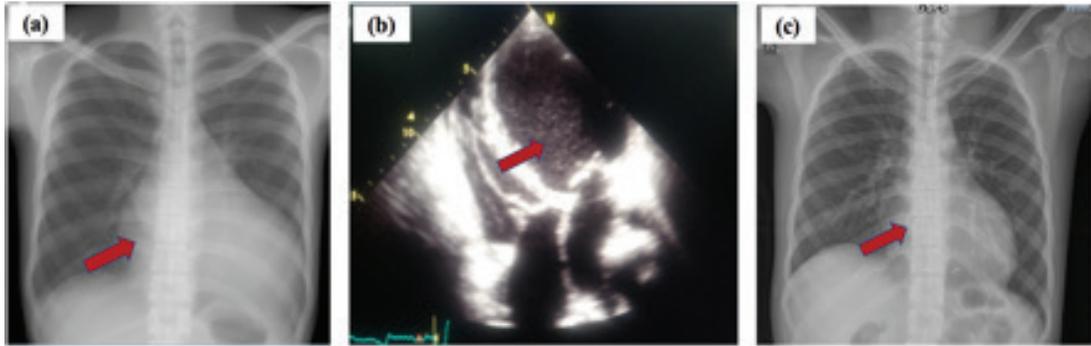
(a). Dilated cardiomyopathy and intramural thrombus (indicated by red arrow) in first case confirmed by chest X-ray. (b). Echocardiography showing a spontaneous echo contrast (indicated by red arrow). Meanwhile in second case, (c) mild cardiomegaly was confirmed by chest X-ray (indicated by red arrow).
